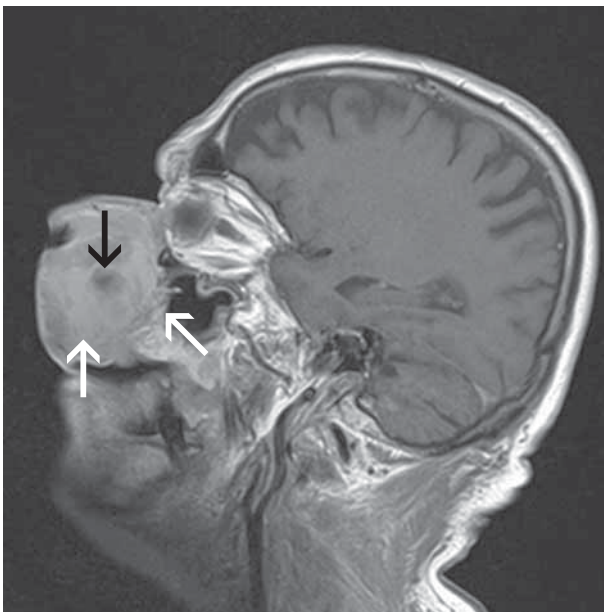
Sagittal contrast-enhanced T1-weighted image shows malignant melanoma with a zone of necrosis (black arrow). Cutaneous and subcutaneous fat tissue, facial and perioral muscles are infiltrated by the tumor (arrows). The bone and cartilage structures of the nose are destroyed.
